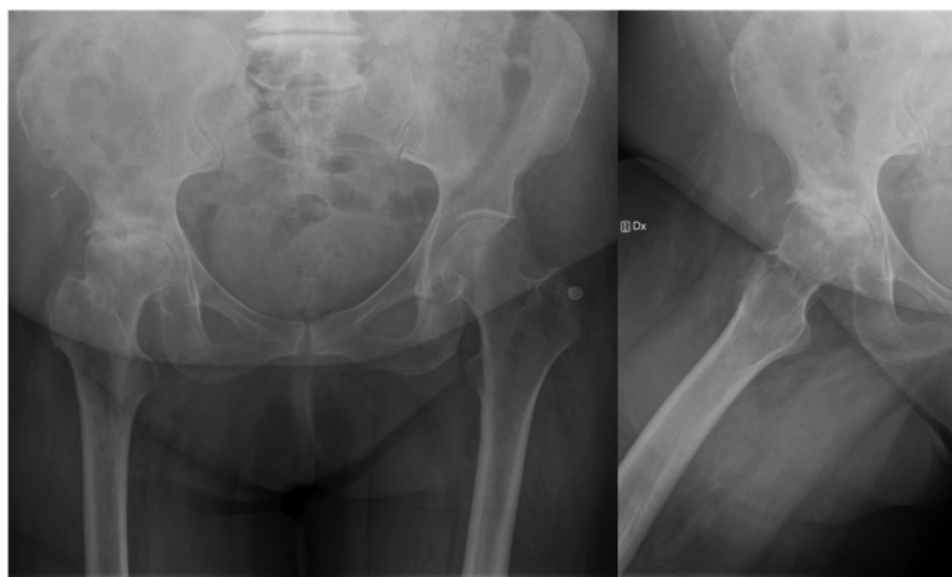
Preoperative radiographs of a 73-year-old female patient with severe osteoarthritis of the hip.
